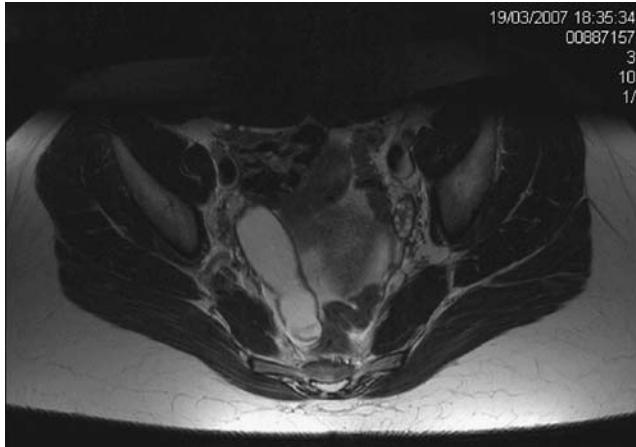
Magnetic resonance imaging (MRI) of the tubular structure
